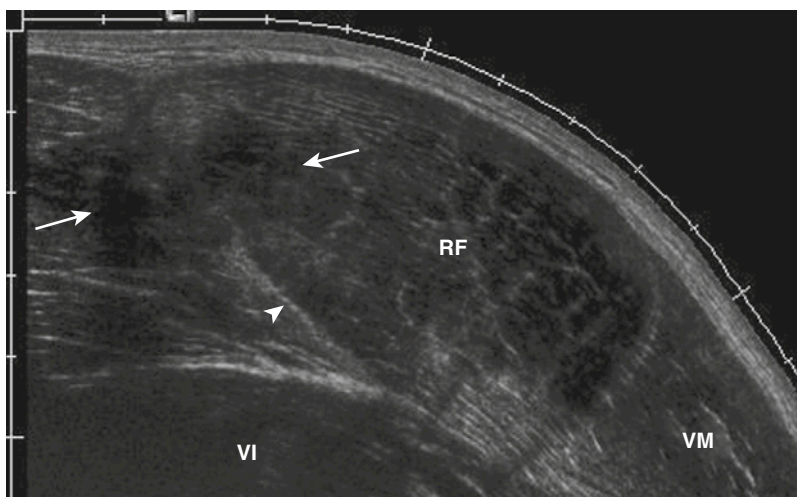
Transverse panoramic view ultrasound shows the vastus intermedius (VI), vastus medialis (VM), and rectus femoris (RF) with a partial (grade 2) tear (*arrows*) at its margin with the vastus lateralis. Notice the intact echogenic epimysium (i.e., aponeurosis) more inferiorly (*arrowhead*).
